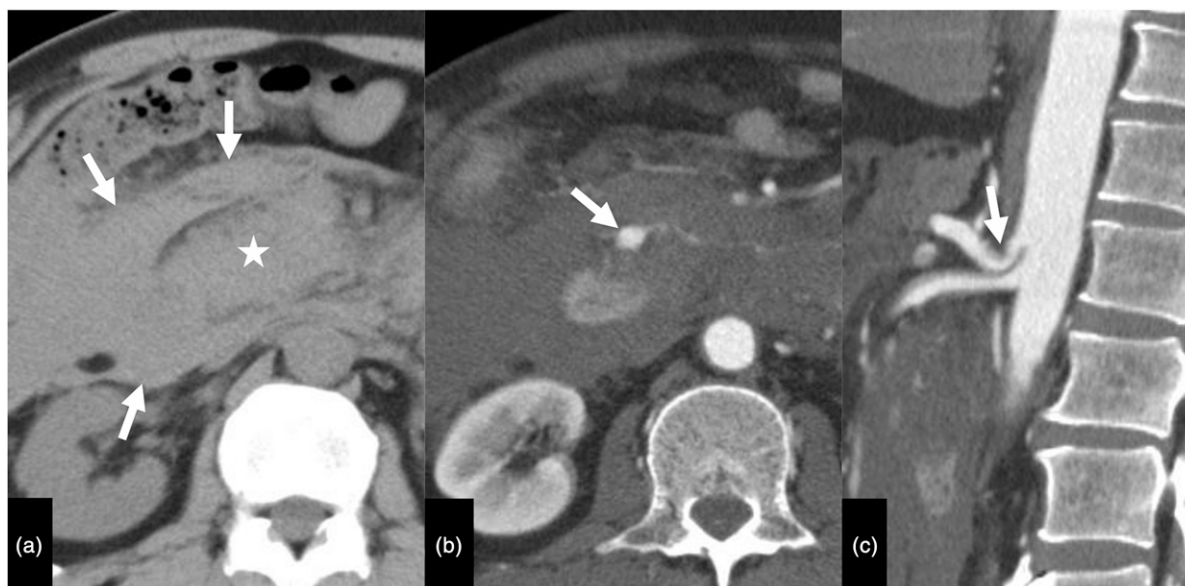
Contrast-enhanced CT in a 53-year-old man presenting with rupture of an anterior inferior pancreaticoduodenal artery (AIPDA) aneurysm due to celiac artery stenosis caused by compression of the median arcuate ligament (case 3). (a) Axial image without contrast medium shows hematoma (arrows) around the pancreatic head (star). (b) Axial arterial-phase contrast-enhanced image shows a pseudoaneurysm (arrow) of the AIPDA. (c) Sagittal arterial-phase contrast-enhanced image shows stenosis and downward compression (arrow) of the celiac artery, which is compatible with compression by the median arcuate ligament.
